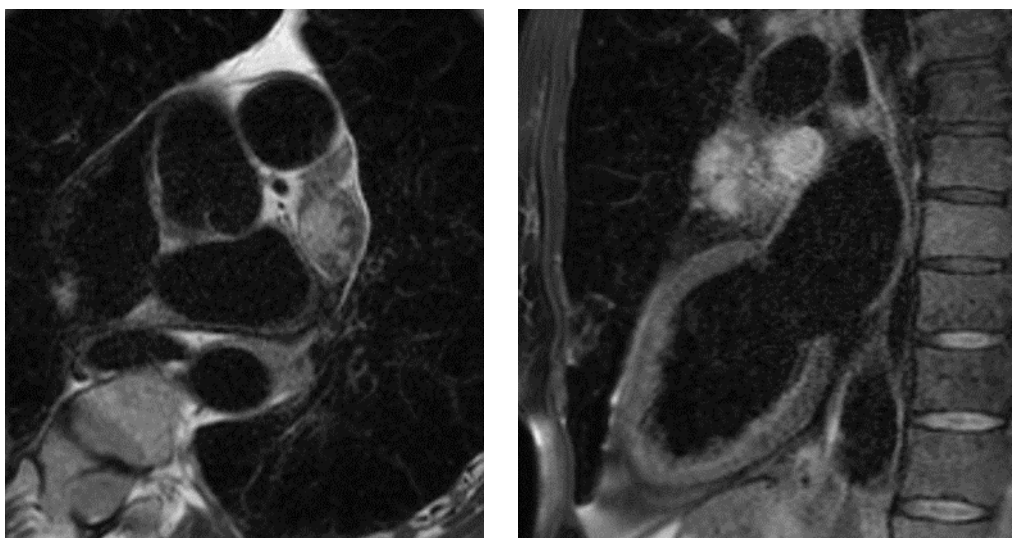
T2 STIR MRI images with fat suppression. A) Transverse section; B) sagittal section. STIR: short tau inversion recovery.
